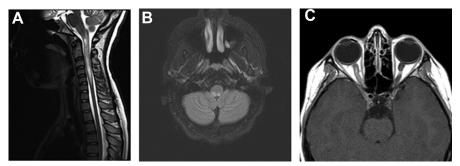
Imaging from a patient with confirmed AQP-4 positive NMO-SD. (*A*) Sagittal FLAIR image shows LETM extending over greater than 3 segments in the cervical spinal cord. (*B*) Axial T2 FLAIR image shows a brainstem lesion associated with area postrema syndrome. (C) Sagittal T2 FLAIR image shows increased signal in the right optic nerve, consistent with ON.
